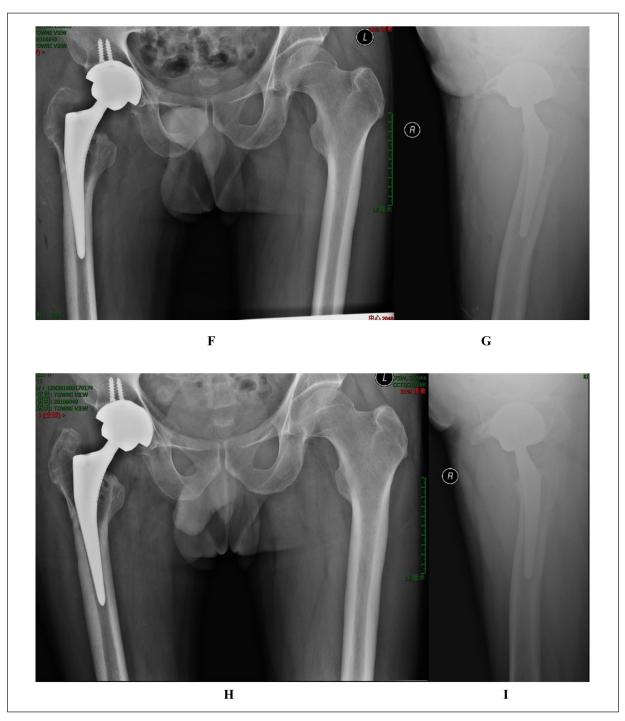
(Continued).* Radiographs of a 50-year-old man showing medial buttress plate combined with hollow screws for femoral neck fracture with nonunion and hollow screws retraction (A-B). The modified Hardinge approach removes hollow screws at the greater trochanter (C). After flexion and external rotation, the medial buttress plate (D) is removed through the front. Femoral head and internal fixation after removal (E). Axial radiographs of the lower pelvis and hip joint showing salvage THA for failed internal fixation (F-G). Prosthesis position at last follow-up (H-I).
